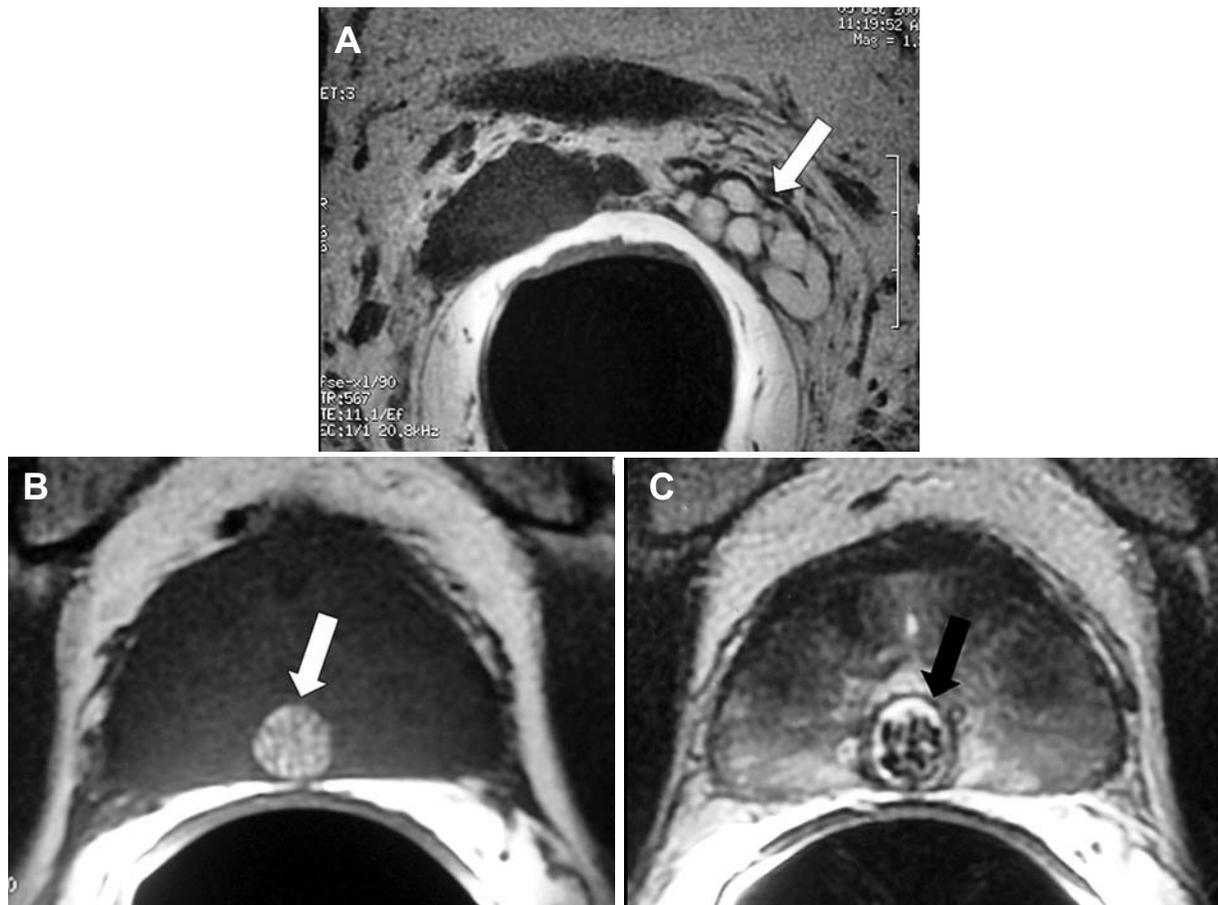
Hemorrhagic seminal vesicle associated with a complicated midline prostatic cyst (utricle cyst). A 54-year-old man, with history of persistent hemospermia. A) E-MRI, axial plane, T1-weighted image, showing a hemorrhagic normal-walled left seminal vesicle (arrow). Hemorrhage is recognized due the presence of high signal intensity on T1-weighted images. B) and C) E-MRI, axial T1 and T2-weighted images respectively, showing a complicated midline prostatic cyst (arrow) containing blood and several small calculi.
